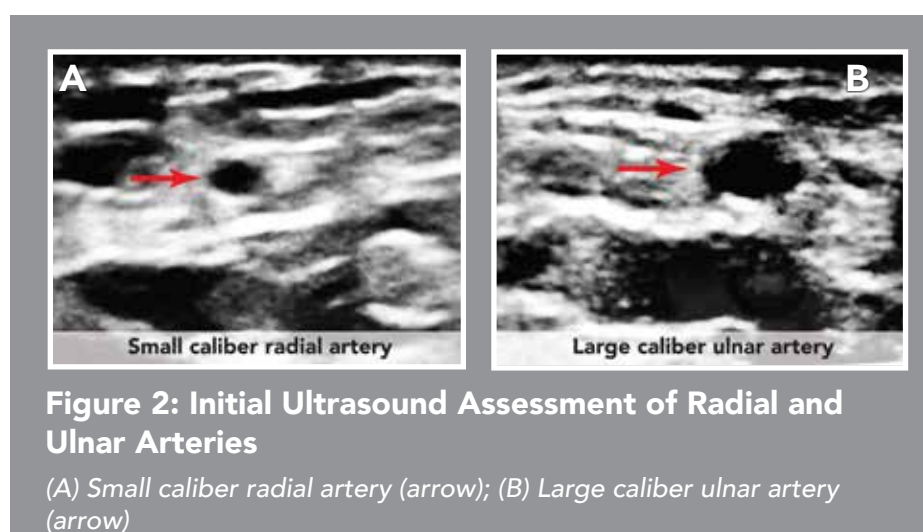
Ultrasound of Lateral Small Radial and Medial Large Ulnar Arteries (video)
